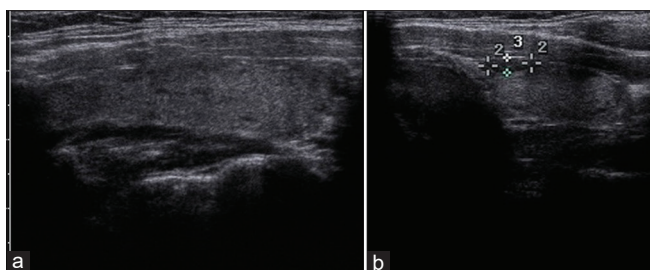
Ultrasound neck images (a: right lobe of thyroid and b: left lobe of thyroid) demonstrating diffusely enlarged thyroid gland with mild heterogeneous echotexture and 0.38 cm × 0.75 cm × 0.26 cm hypochoic solid nodule in left lobe
